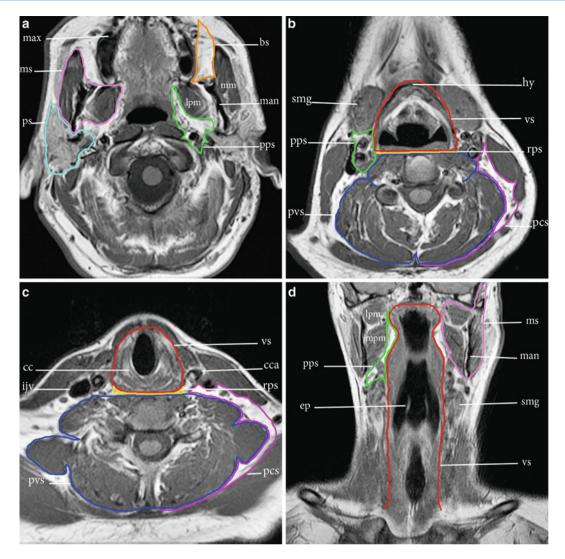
Deep spaces of the neck are outlined on serial axial T1-weighted MR images. Parotid space (*ps*), masticator space (*ms*), parapharyngeal space (*pps*), buccal space (*bs*), visceral space (*vs*), retropharyngeal space (*rps*), perivertebral (*pvs*), posterior cervical space
